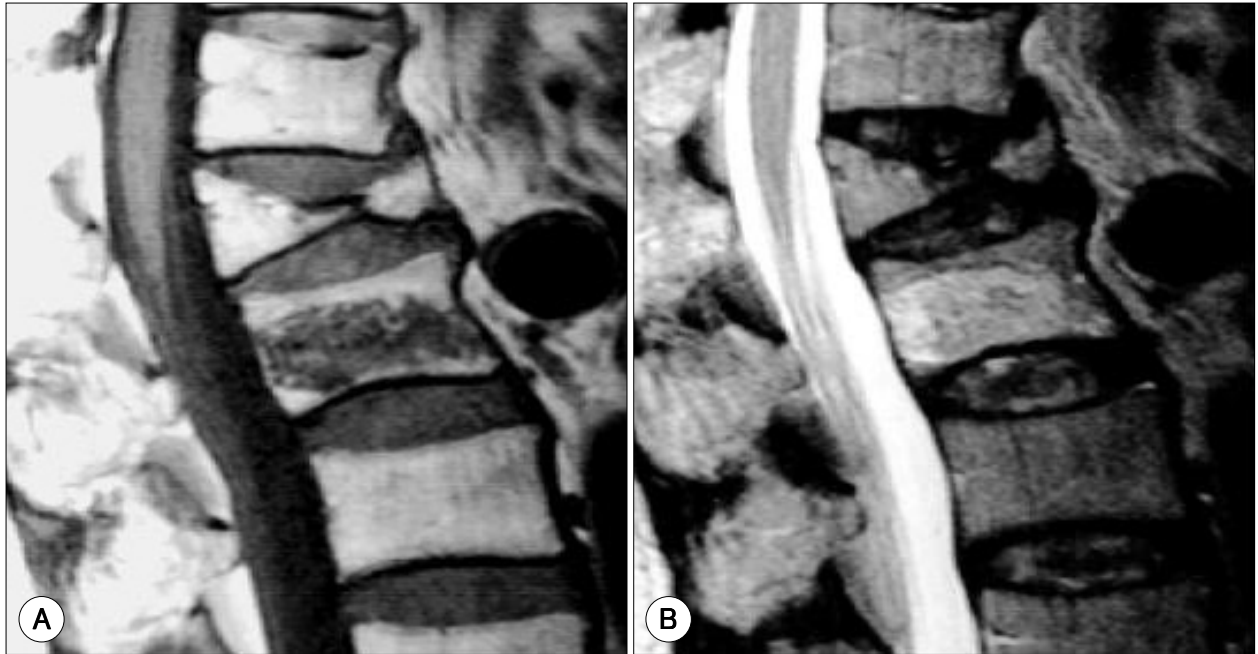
MR image in a 72-year-old woman showing acute fractured evidence below the suspicious old fractured body. MR finding of acute compression fracture revealing low signal on T1WI(A) and high signal on T2WI(B). PMMA injection was introduced into the acute fractured body site.
